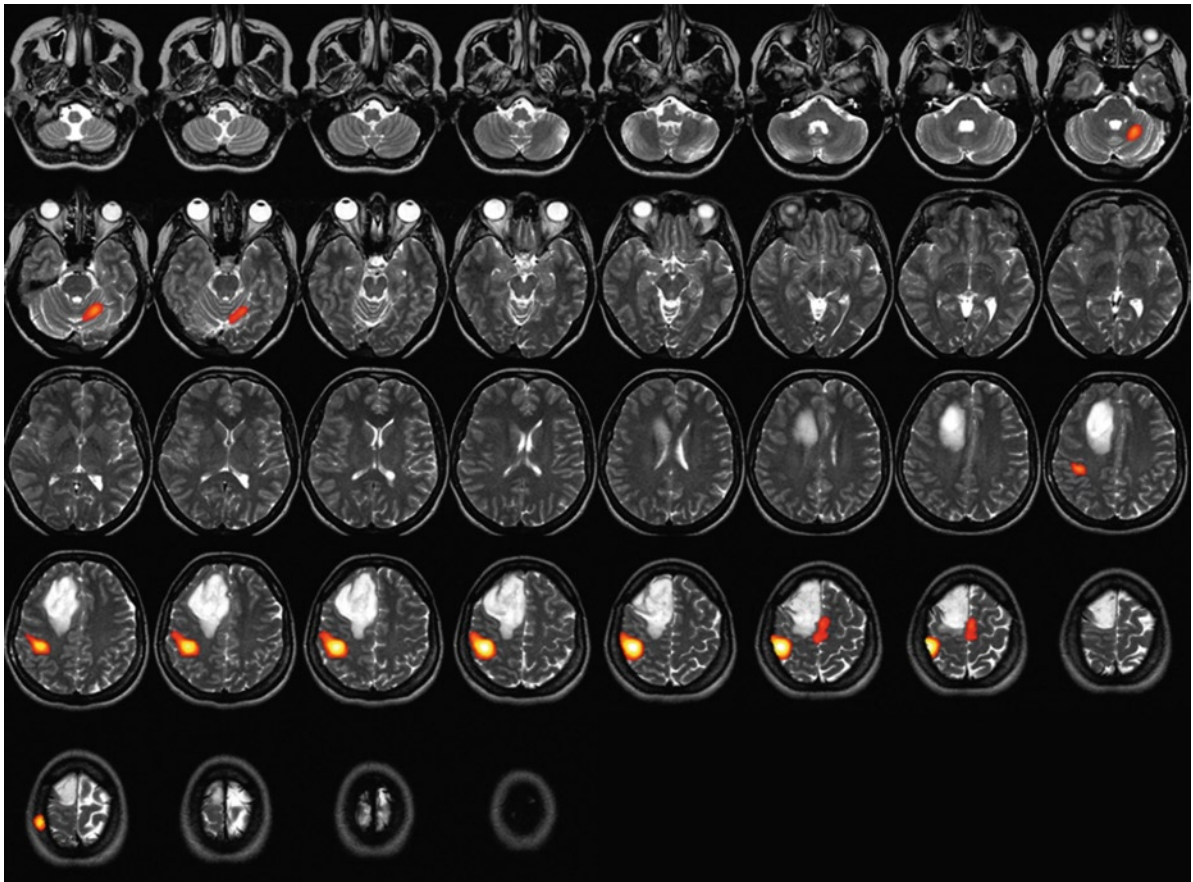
Motor cortex activation during a finger tapping experiment in a patient with a high-grade tumor. Areas of activation are superimposed on axial T2-weighted images
